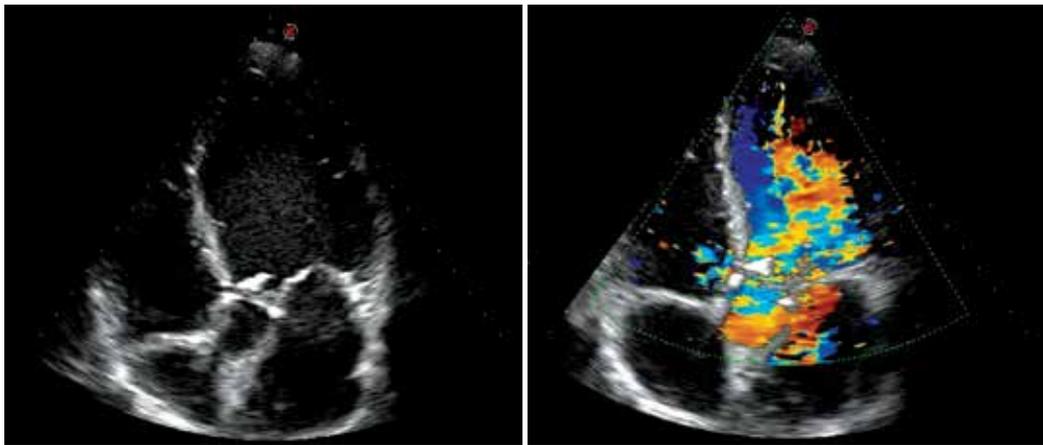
Native aortic valve vegetation (left TTE and right color Doppler ultrasound)
